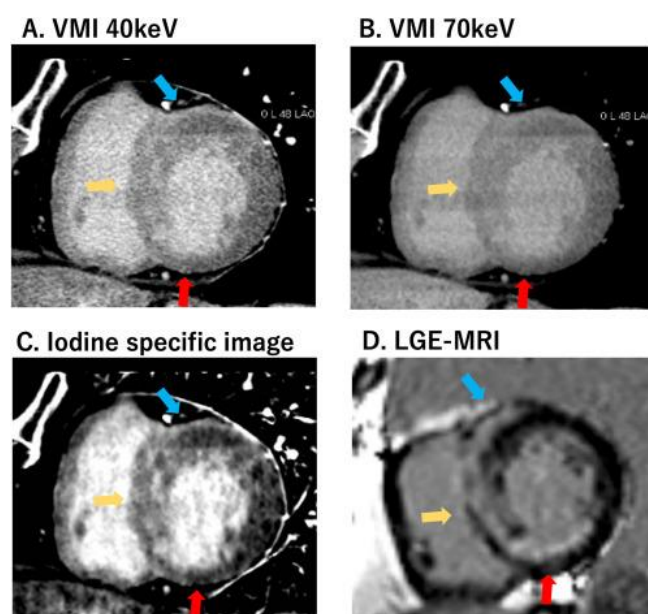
LIE-CT imaging using DECT in a patient presenting with a blocked right coronary artery and cardiac sarcoidosis. The myocardial LIE-CT image indicates subendocardial infarction in the inferior wall (red arrow), striated non-ischemic enhancement (yellow arrow) in the mid-wall of the interventricular septum, and non-ischemic enhancement (blue arrow) in the epicardium of the anterior wall. The lesion contrast appears higher in the virtual monoenergetic images of 40 keV (A) and the iodine-specific images (C) compared to the 70 keV image (B). These findings are consistent with those observed in LGE-CMR (D). Modified from Oyama-Manabe et al. [50].
